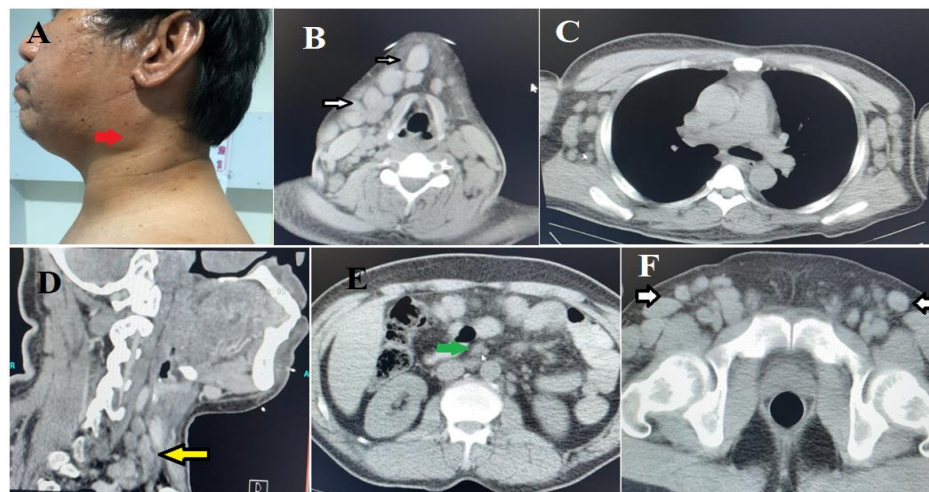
Clinical feature and Computed tomography. (A) Multiple cervical lymphadenopathies on the right side, (B, D) CT scan, Submental and Medial jugular lymphadenopathy, (C) Bilateral axillary lymphadenopathy, (E) Intra-abdominal para-aortic lymphadenopathy, (F) Bilateral inguinal lymphadenopathy.
